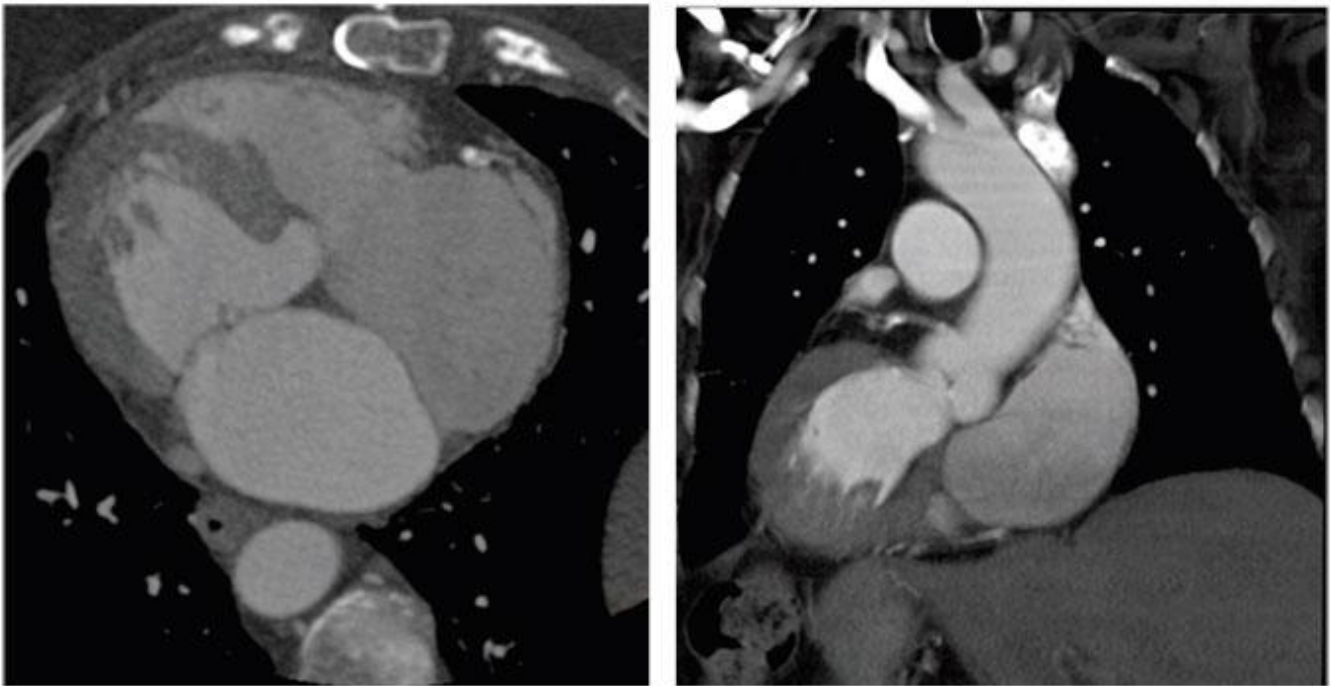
Slice CT angiography images.
